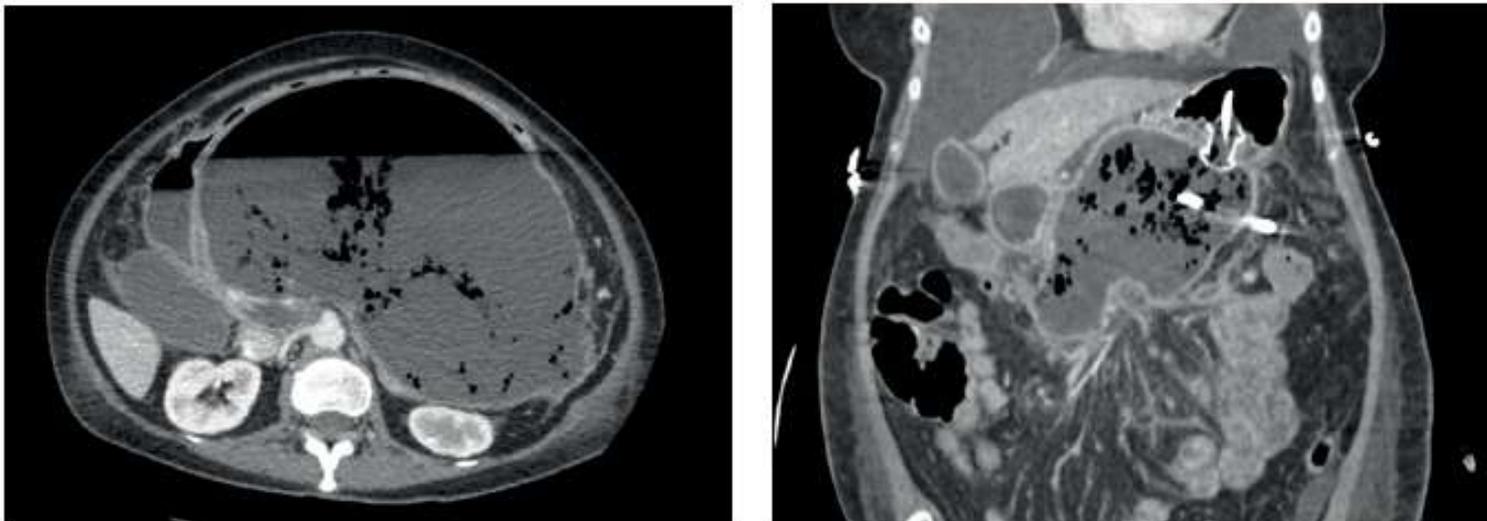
Left: Contrast enhanced computed tomography scan showing a large area of walled-off necrosis with a mature wall, an air-fluid level, and gas in solid necrotic material implying infection. Right: A luminal opposing stent has been placed between the stomach and the walled-off necrosis, and a pigtail drain runs through the center of the stent. The patient has also had a percutaneous drain placed
